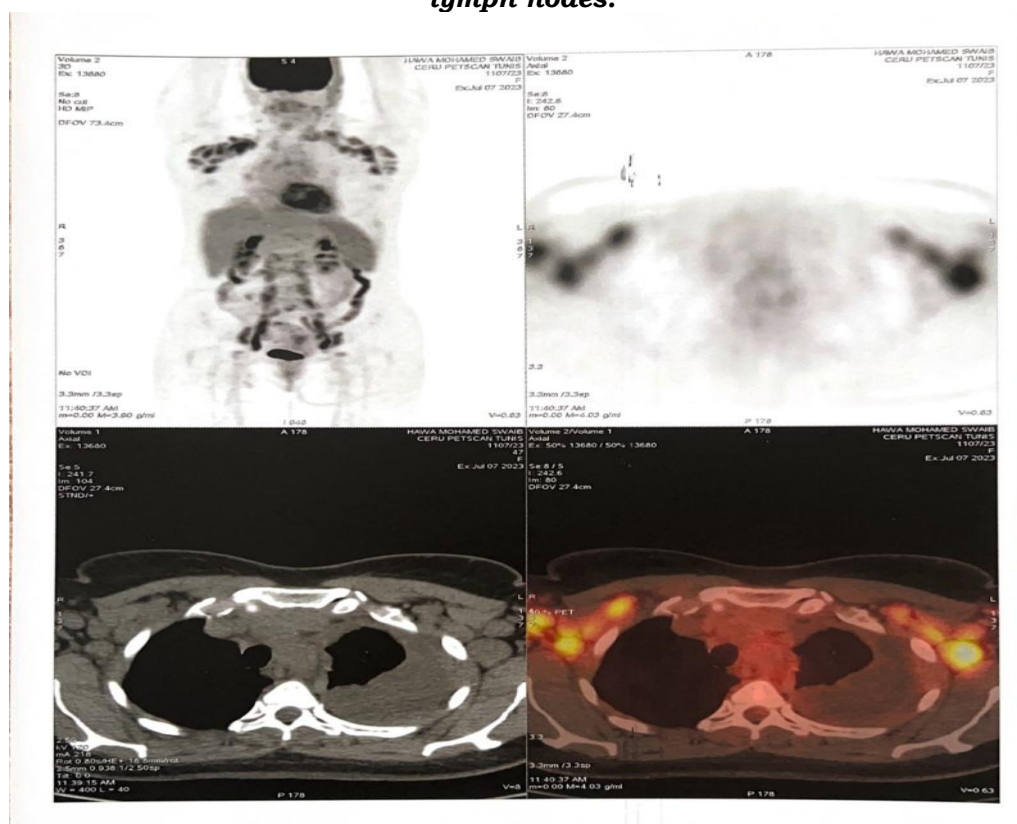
PET-CT scan showing extensive mediastinal and axillary lymphadenopathy, alongside a left-sided pleural effusion.
